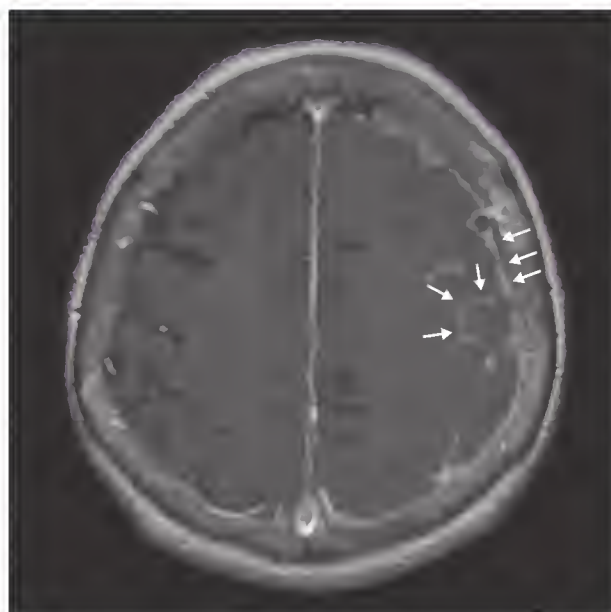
Rheumatoid arthritis–associated meningitis in a patient with headache and fever. Magnetic resonance imaging shows abnormal leptomeningeal enhancement, especially of the left parietal and frontal lobes and temporal dura (arrows).
